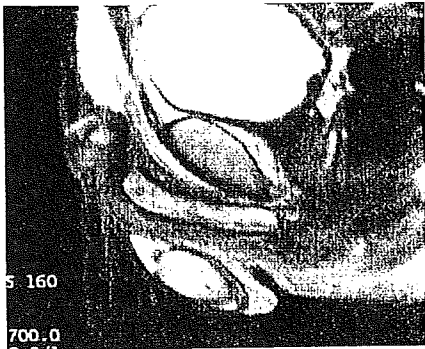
T2-weighted MRI findings after treatment (January 2005). Note the disappearance of high-intensity areas in the periurethra and testes.
